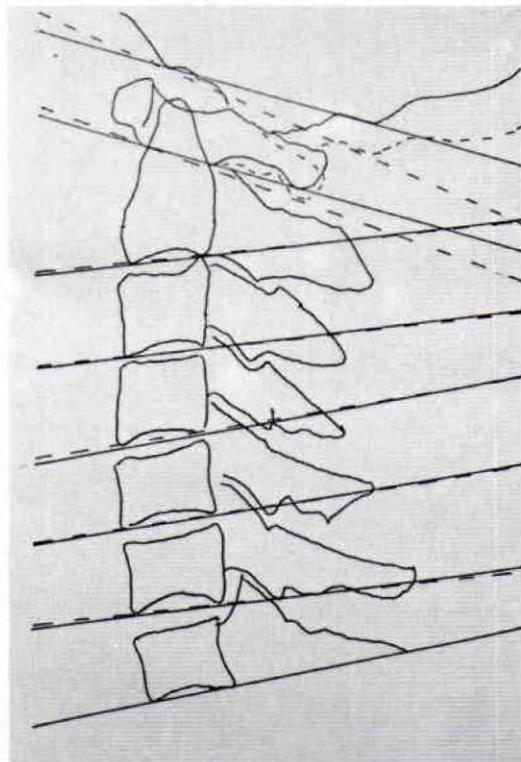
A sketch of an X-ray picture of vertebrae after application of the FOZY Orthosis to a normal adult. The solid line represents flexion and the dotted line represents extension. It shows that large movement is well controlled but upper cervical vertebrae remain able to move 5-10 degrees.
